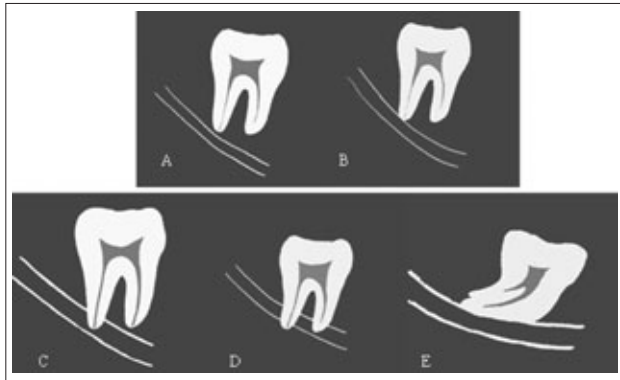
All of the IMTMs were classified into three classes according to the relationship between the IMTM and the IAC detected on panoramic radiographs: class A: the IMTMs did not touch the canal (Fig 1A); class B: the apex of the IMTM touched the canal (Fig 1B); class C: the IMTM superimposed the canal partly, or touched the canal in line (Fig 1C, D and E).
